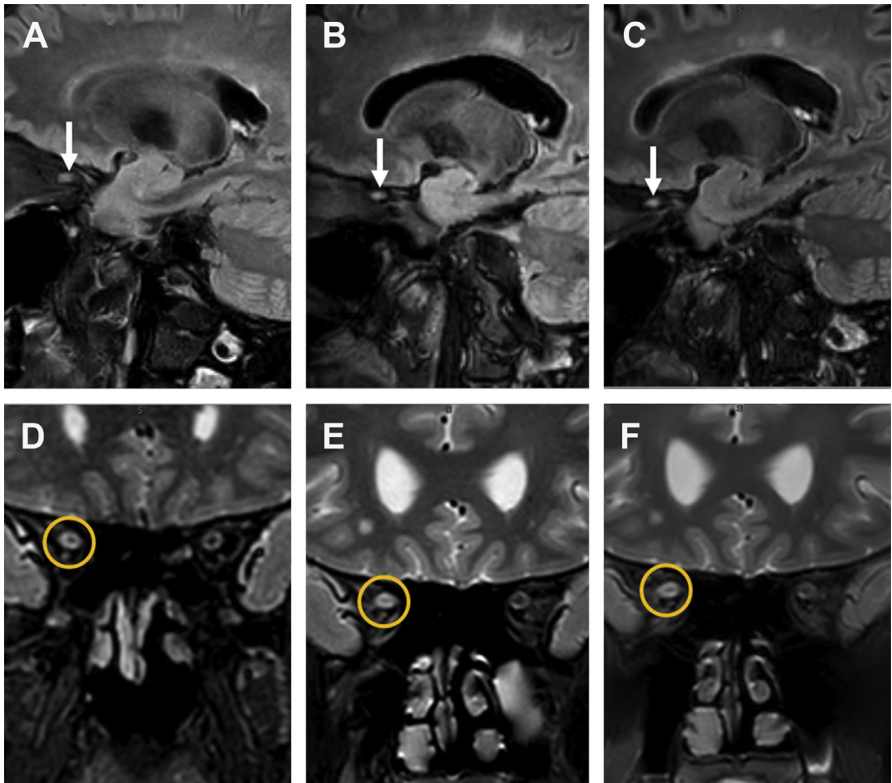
Serial imaging of optic neuritis. On the sagittal 3D FLAIR, the right optic nerve shows a short, segmental hyperintensity that stands out against the background (*arrow* in A–C). On coronal fat-suppressed T2-weighted images, the affected nerve is depicted with smaller caliber and higher signal intensity compared with the normal left optic nerve (*circled area* in D–F). During the course of the longitudinal follow-up, the abnormality shows up consistently on both sequences and is more conspicuous on the 3D FLAIR. This draws attention to the broad utility of 3D FLAIR in imaging of multiple sclerosis.
